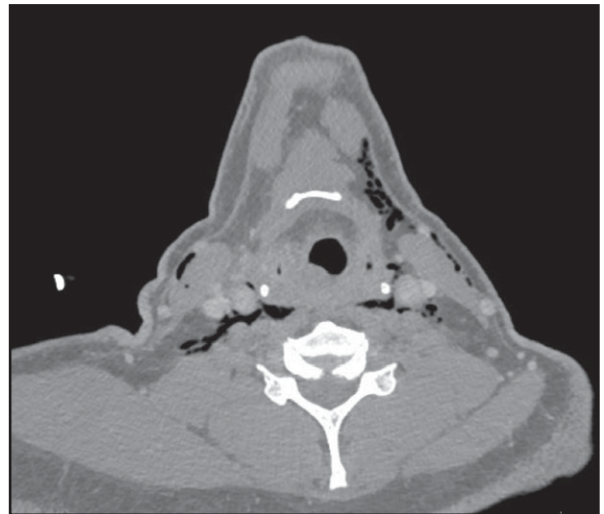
Subcutaneous emphysema noted on diagnostic neck computed tomography (CT).
